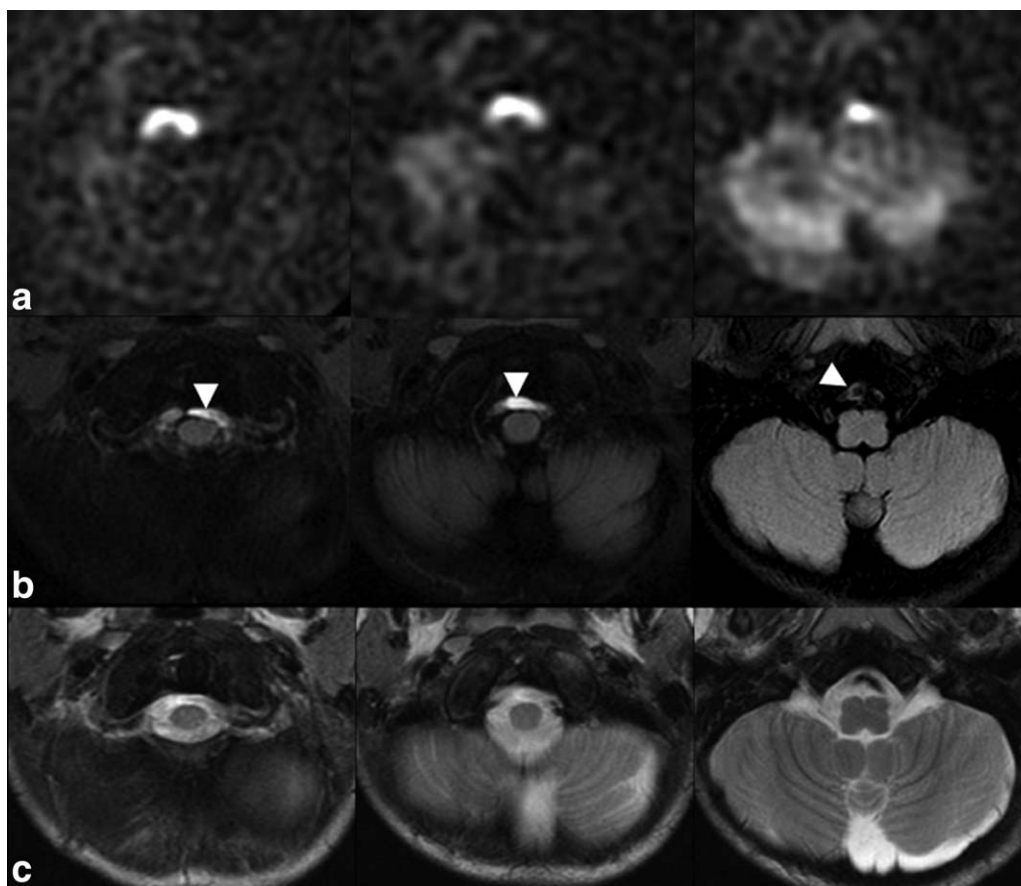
CSF labeling. a: High signal is seen anterior to the medulla and the junction of the medulla and upper cervical spinal cord on ASL maps. Fast spin-echo FLAIR (b) and T_2 -weighted (c) imaging demonstrates no extra-axial lesion in this location, and confirms that the signal localizes to the CSF space. The characteristic location of high signal within the premedullary CSF cistern, in a ring-like or hemi-annular pattern, alerts the reader that this is an artifact, caused by CSF labeling and pulsation; CSF water protons that are labeled at the skull base due to their pulsatile motion subsequently appear in the inferior imaging sections. CSF pulsation is also evidenced by failure of CSF suppression on the FLAIR images (B, white arrowheads).
